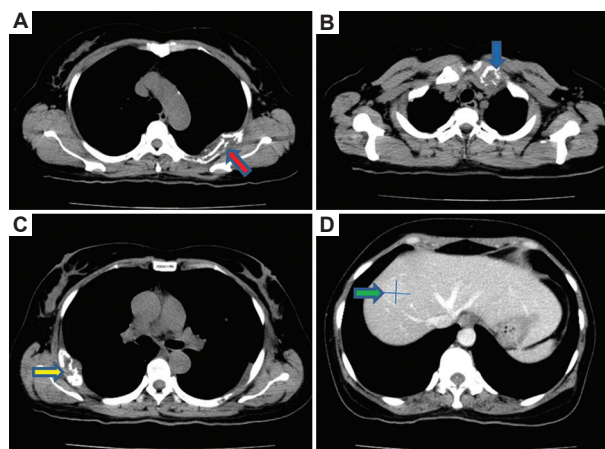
Chest and abdominal computed tomography scans. (A–C) Secondary multifocal bone lesions. Secondary multifocal bone lesion in left IV rib arches (A - Red arrow), left sternoclavicular joint (B - Blue arrow), right rib V (C - Yellow arrow). (D) Mass in the right lobe of the liver; biopsy showed no malignant cells (green arrow).
